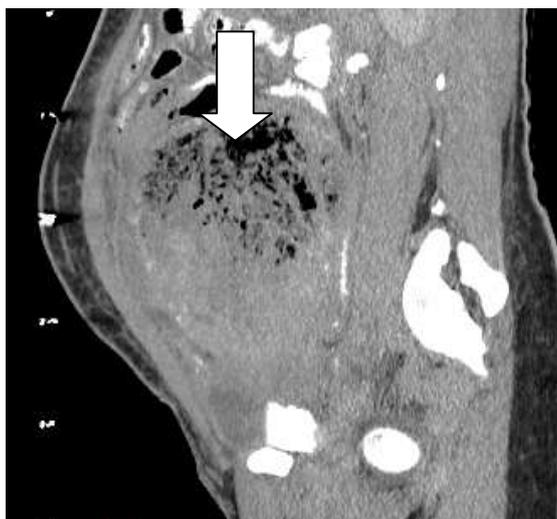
Contrast enhanced sagittal CT of the abdomen showing an intra-abdominal gas-containing mass (gossypiboma) in a 35-year-old woman with a prior history of myomectomy who presented with abdominal swelling, increasing abdominal pain and fever.(arrow)
